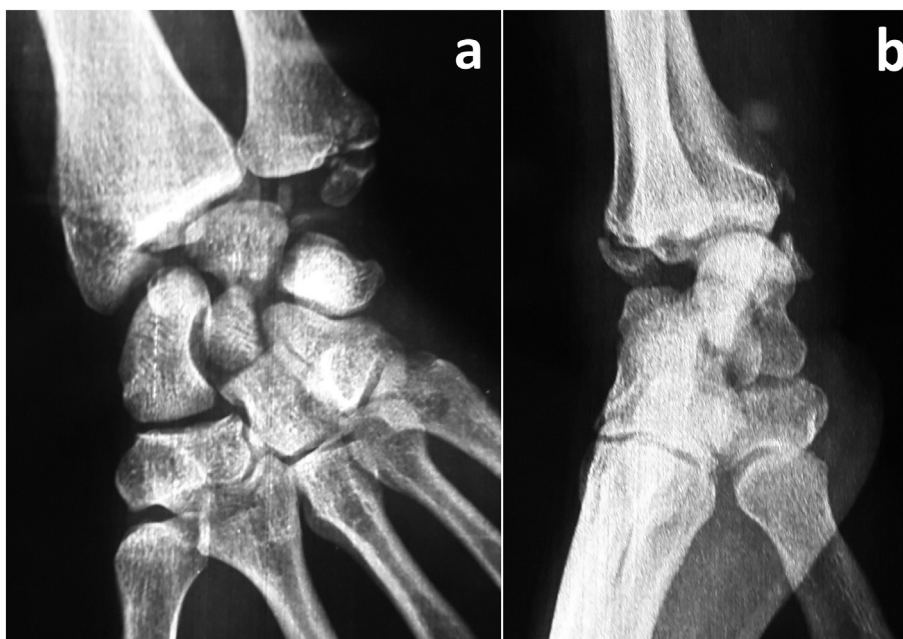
Posteroanterior (a) and lateral (b) radiographs of the right wrist at admission: Retro-lunar dislocation of carpal bones with transverse fracture of the capitate, anterior displacement of the lunate with fracture-enucleation of a part of its anterior horn, radial styloid fracture and ulnar styloid fracture.
